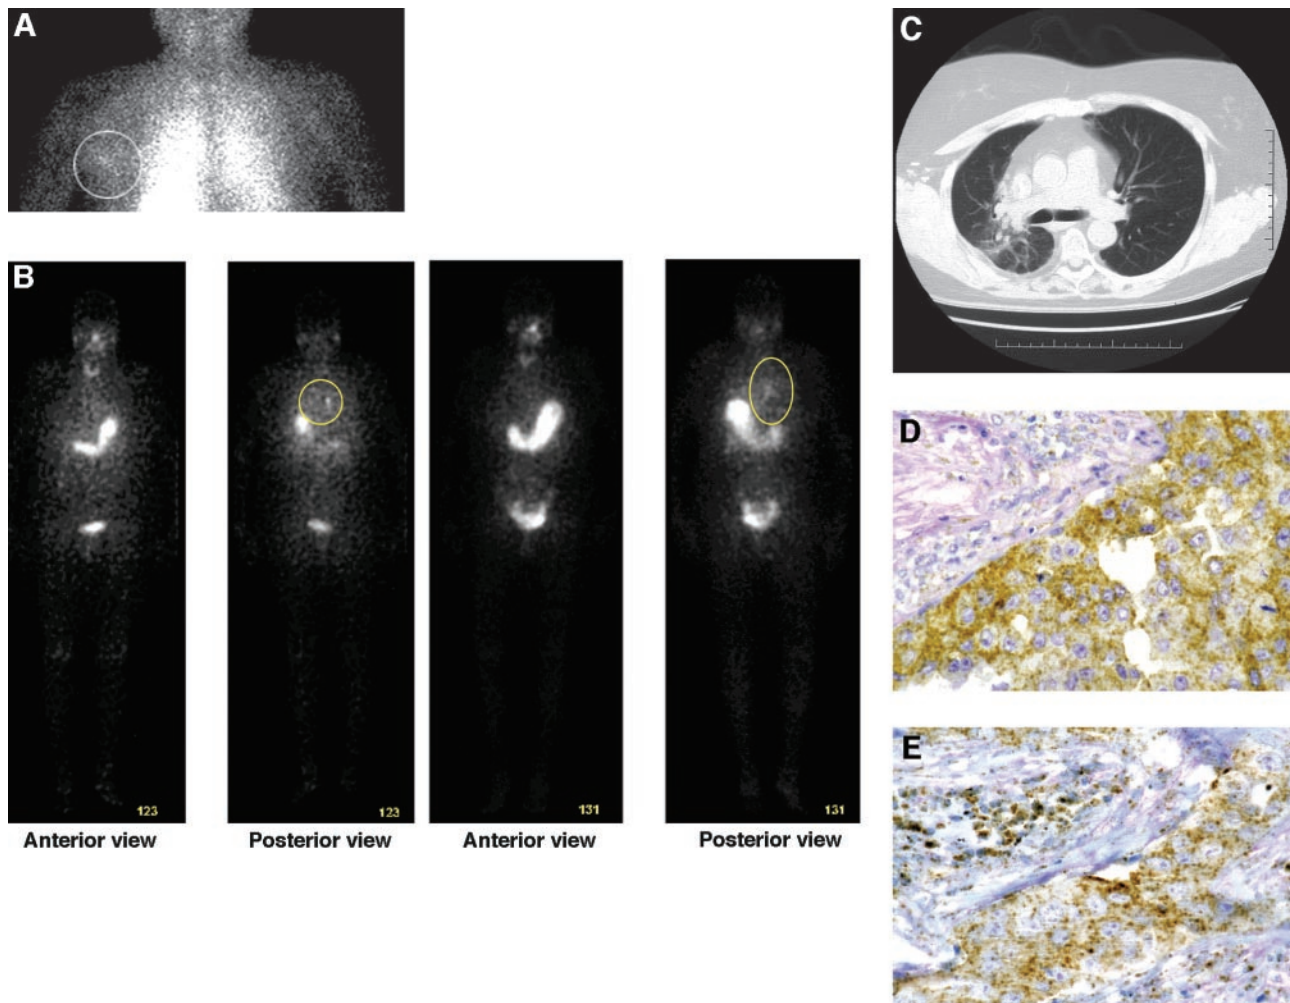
^{99m}Tc -pertechnetate, ^{123}I , and ^{131}I uptake scans in Na^+/I^- symporter (NIS)-positive metastatic breast cancer. A, ^{99m}Tc -pertechnetate scan showing uptake at 30 min in axillary metastasis indicated by *circle*. B, ^{123}I scintiscan performed after a 10-day course of T_3 thyroid-suppressive treatment (TSH; 0.088 $\mu\text{IU}/\text{ml}$). Anterior and posterior projection is shown here taken at 4 h. Tracer is noted in the stomach, small bowel, and bladder. Accumulation is seen in the perihilar region of the right lung (*yellow circle*) at the site of metastasis on the posterior view only. Similar images represent ^{131}I scans obtained months later. C, computed tomography scan of chest performed weeks before ^{131}I scan shows an irregular mass in the region of the right hilum (*black arrow*) corresponding to the bronchoscopy proven breast cancer metastasis. D, primary invasive ductal carcinoma of the breast showing 3+ immunoreactivity to anti-NIS antibody. Because of the strong immunoreactivity, presence or absence of plasma membrane immunopositivity cannot be discerned, original magnification, $\times 60$. E, focally intense NIS immunoreactivity in malignant breast cells metastatic to lung, original magnification, $\times 30$.
